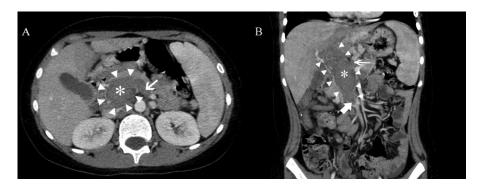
Portal vein aneurysm thrombosis on abdominal, contrast-enhanced computed tomography. Contrast-enhanced computed tomography images through the axial (A) and coronal (B) planes. The thrombosis (asterisk) appears diffuse throughout the portal vein (arrowheads), the splenic vein (thin arrow), and the superior mesenteric vein (thick arrow)
